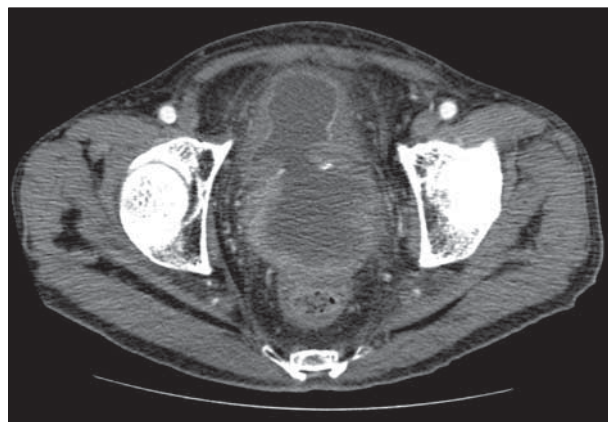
Axial computed tomographic image of the pelvic mass demonstrating direct extension to the rectum and a fistula to the urinary bladder.
